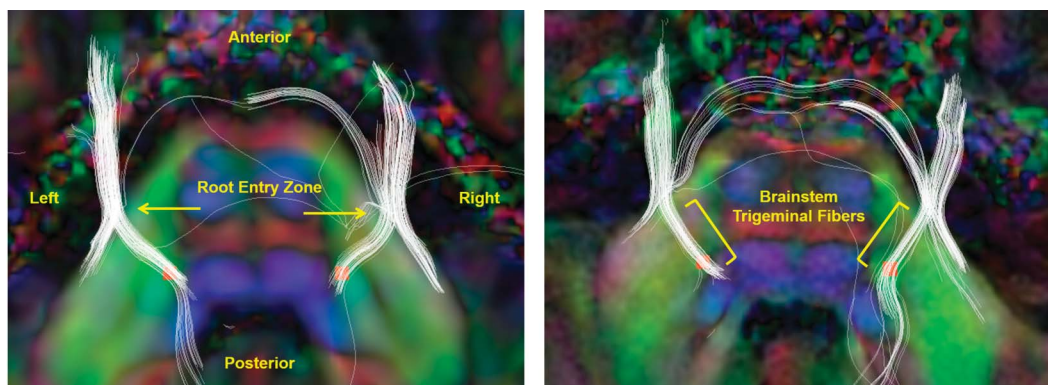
Multitensor diffusion tractography of the trigeminal nerves and ROI placement. Panels represent tractography of the trigeminal nerves (in white) and ROI placement at the proximal pontine segment (in red) in axial view for 2 example participants. The fiber tracts are superimposed on coregistered semitransparent T1-weighted anatomical and underlying diffusion tensor images. The diffusion tensor images are colored by orientation (red, left–right; green, anterior–posterior; and blue, superior–inferior). (Left panel) Arrows indicate the root entry zone of the trigeminal nerve, where tractography is generated from. (Right panel) Brackets indicate the brainstem trigeminal fibers, which are used to guide ROI placement at the proximal pontine segment for DTI metric extraction. DTI, diffusion tensor imaging; ROI, region of interest.
